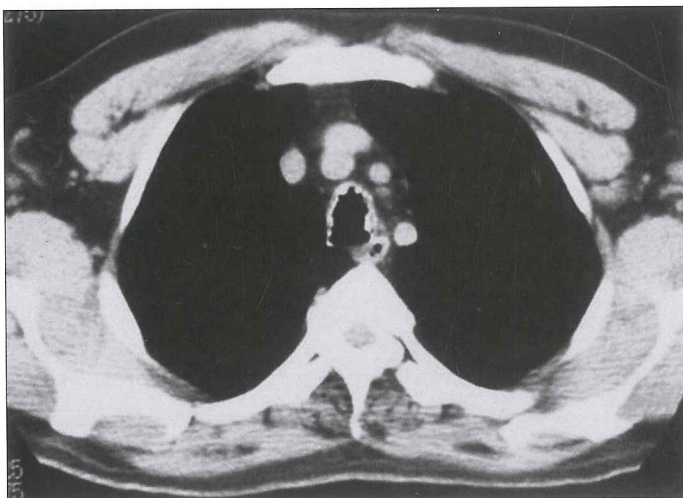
CT scan shows the mucosal irregularity with calcification in anterior and lateral walls of the trachea. The posterior membranous wall is intact
